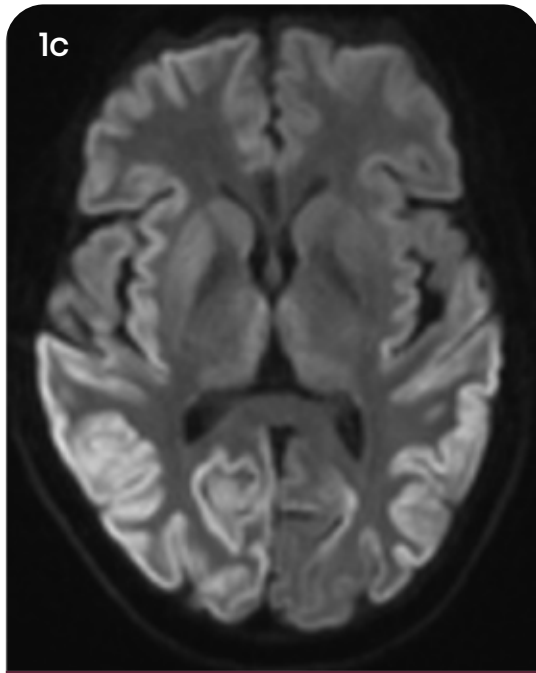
Gyriform hyperintense signal along cerebral cortex on DWI in bilateral inferior parietal lobule and parietal operculum.
